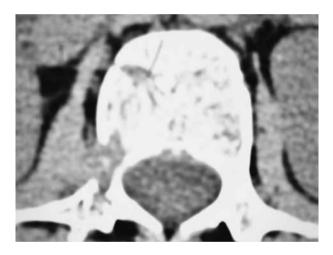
Preoperative CT-scan, transverse view. Osteolytic lesion of the right pedicle of L2.
